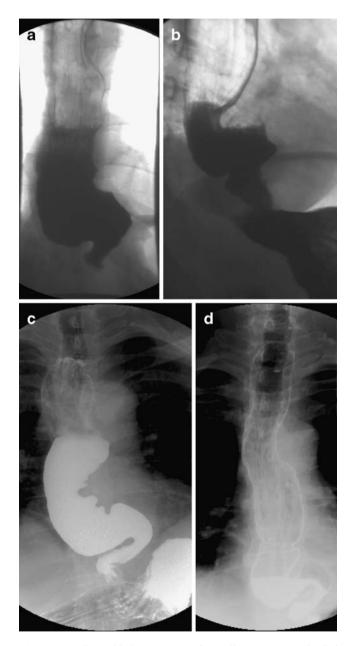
Radiographic improvement after Heller myotomy and relief of distal esophageal obstruction (a, c preoperative; b, d postoperative). a Sigmoidal esophagus prior to Heller myotomy. b Improved emptying of sigmoidal esophagus immediately following Heller myotomy. c Significant dilation and sigmoidal changes prior to Heller myotomy. d Decreased distension and sigmoidal angulation, as well as improved emptying, 3.5 years after Heller myotomy.
